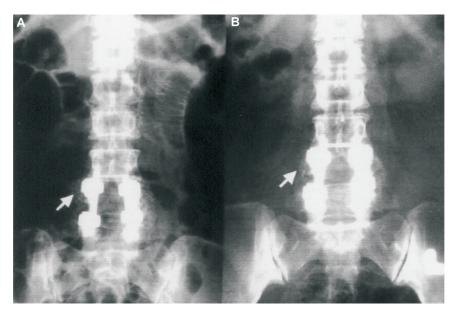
(A) Immediate post-op anteroposterior radiograph of the lumbar spine with the bone chip graft placed over the bilateral paravertebral lumbar gutters (arrow). (B) Anteroposterior radiograph at 8 months post-op demonstrating a well-consolidated lateral fusion mass (arrow).
